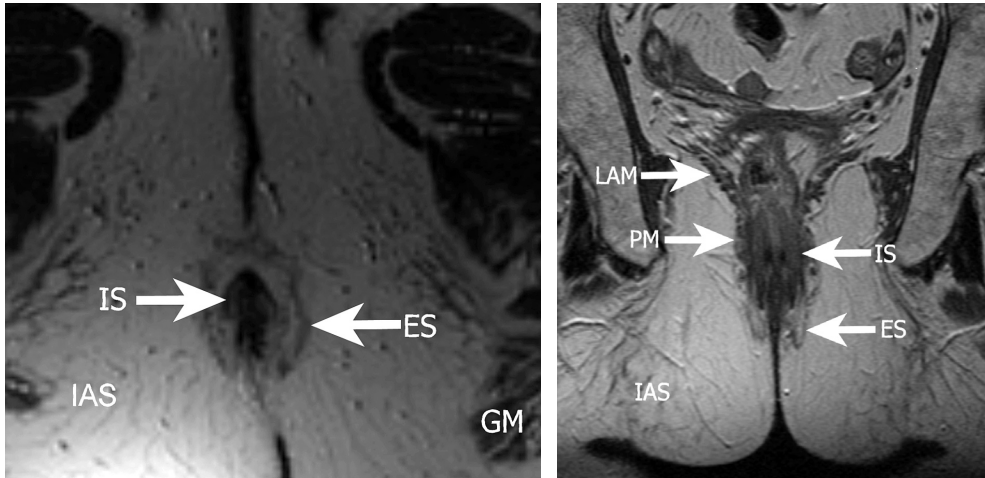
^a, 21^b. (21^a) Transverse T2-weighted fast spin-echo (2500/70) external phased array MR image and (21^b) coronal T2-weighted fast spin-echo (2500/70) external phased array MR image showing severe thinning of the external anal sphincter (ES) and diffuse replacement by fat in a 69-years-old fecal incontinent woman with no risk factors for pudendal nerve damage in the past. IS = internal anal sphincter, IAS = ischioanal space, PM = puborectal muscle, LAM = levator ani muscle, GM = gluteus muscle
